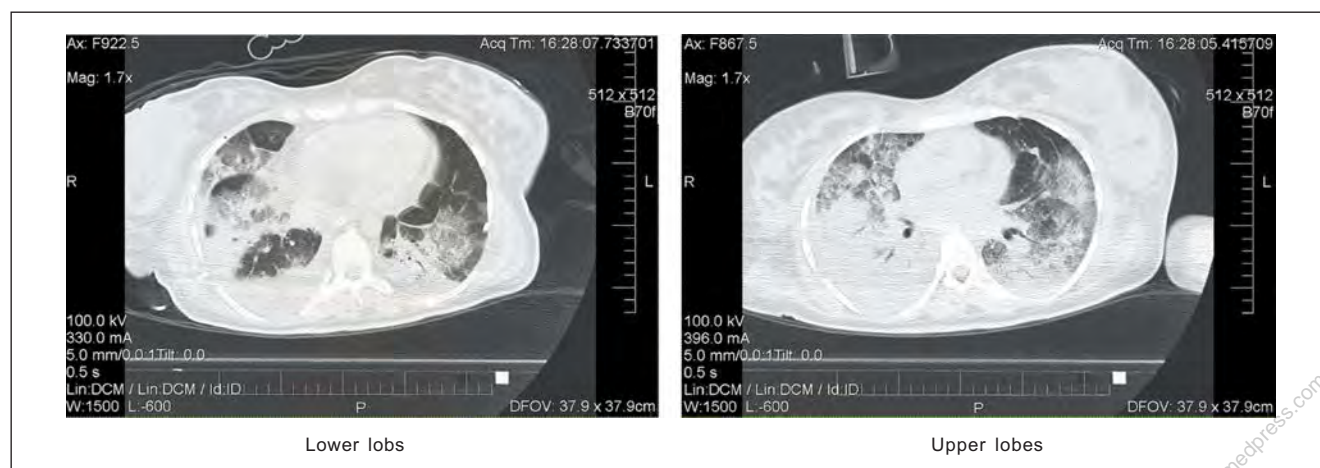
Angio-CT revealed massive lung involvement. In the right lung, the pulmonary parenchyma affected by inflammation reached 80-90%, in the left – 70%. Moreover, the image of a milk glass opacity in the upper lobes characteristic for COVID-19 was detected
